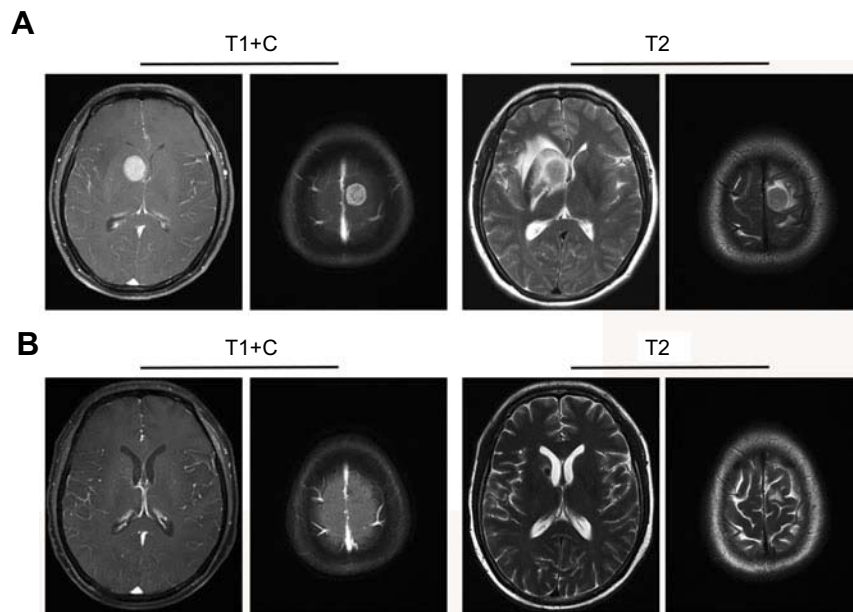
MRI detection of brain metastasis and an MRI scan after curative radiotherapy. (A) Contrast-enhancement T1-weighted images revealed an enhanced solitary mass 19×22×25 mm in size with a surrounding area of low intensity in the right basal ganglia, associated with left frontal lobe metastases. (B) One month after curative radiotherapy, the MRI scan showed that the brain metastatic tumoral volume was significantly reduced and had disappeared.
